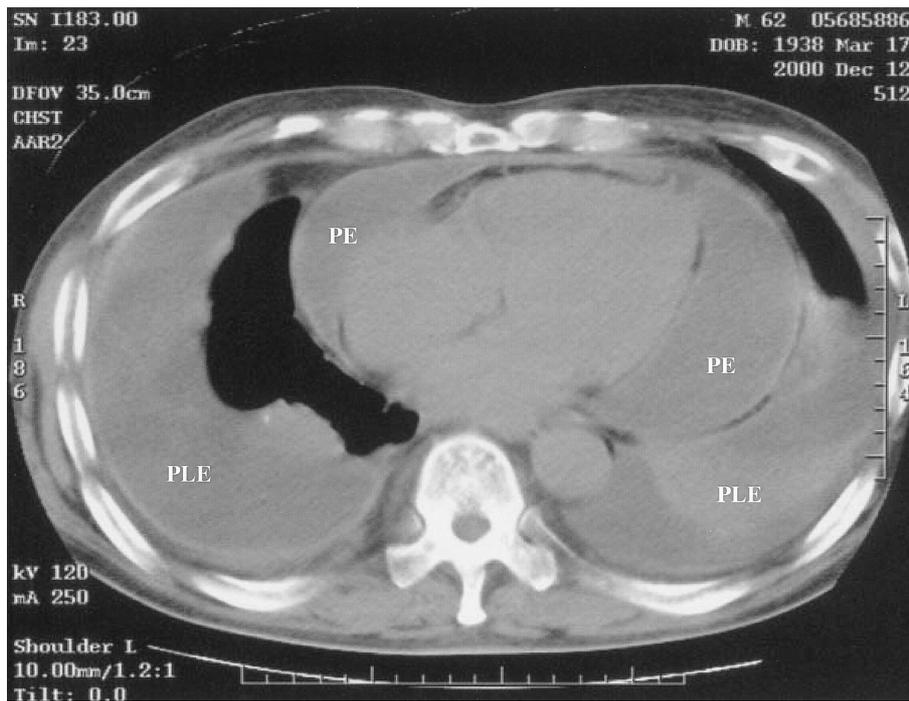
Computed tomography of the chest on admission : A diffusely thickened pericardium with a large amount of pericardial effusion and pleural effusion was seen. PE : pericardial effusion, PLE : pleural effusion.
